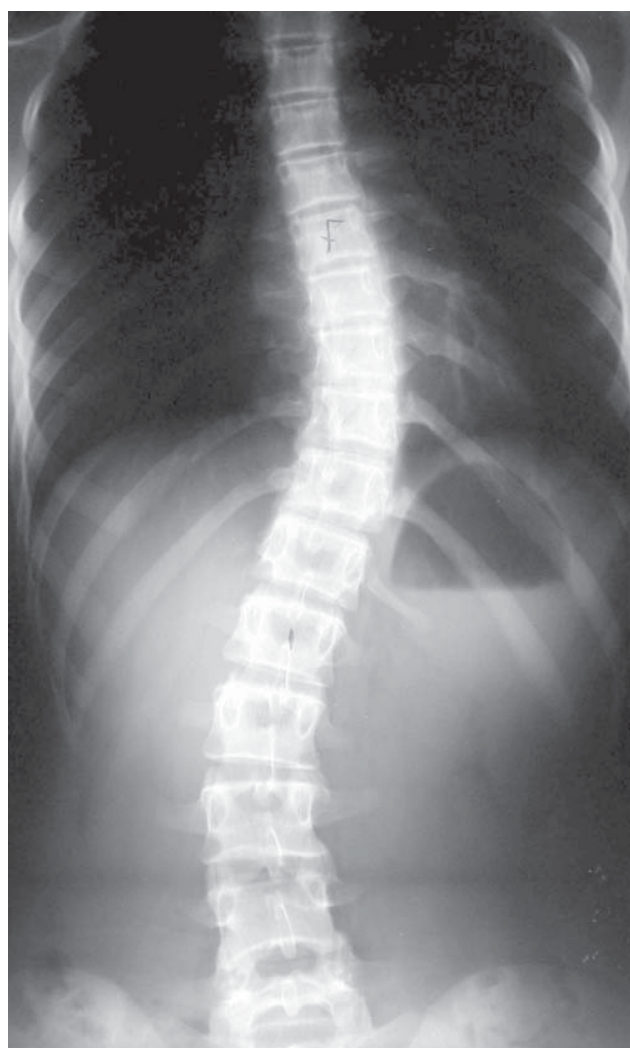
PA radiograph of the spine demonstrating a non-dystrophic curve pattern in NF-1
